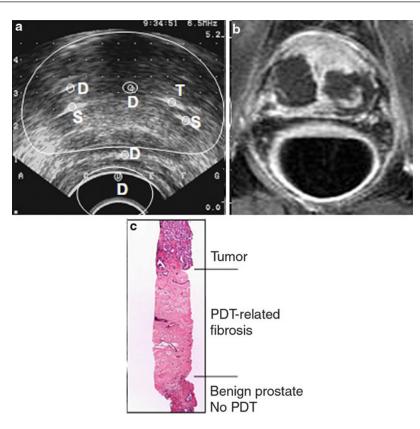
(a), Transverse view of prostate under transrectal ultrasound. *White areas* indicate fibers. *Outlines* indicate prostate, urethra, and rectum. *S* Source fibers, *T* Temperature probe, *D* Light dosimetry fibers are positioned in urethra, rectum, and hydrodissection space between rectum and prostate. (b), Post-gadolinium-enhanced MRI 7 days after VTP in patient with 2 mg/kg drug dose and 360 J/cm light dose demonstrates necrotic regions. Note large lesions in each lobe.
